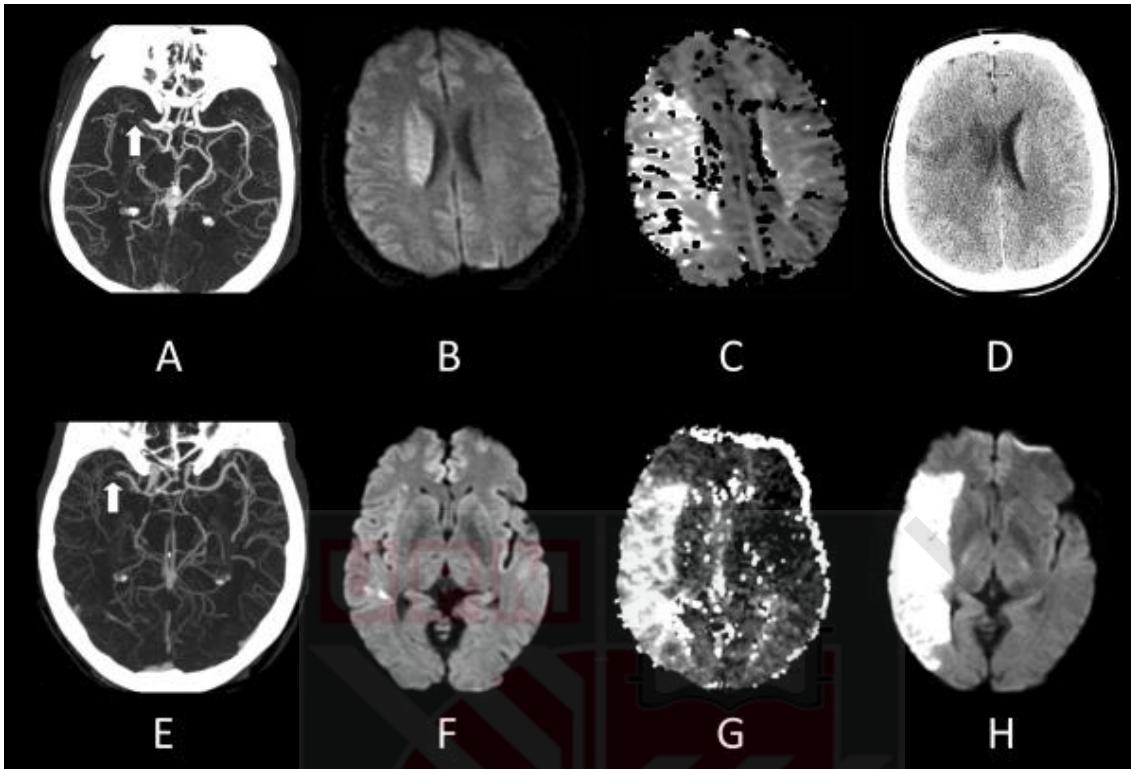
which was depicted from González R. G. (2012). Clinical MRI of Acute Ischemic Stroke shows:
